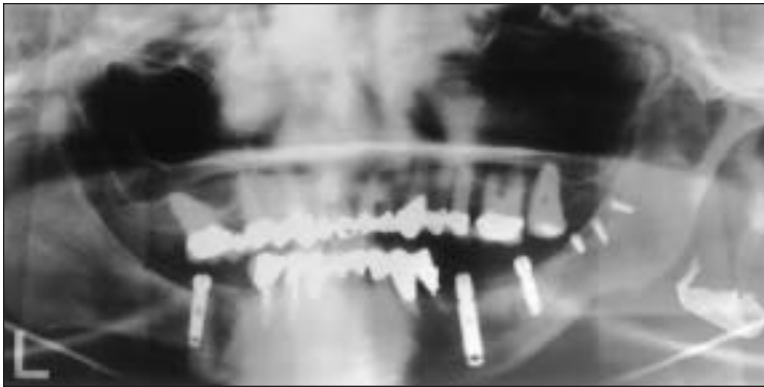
Panoramic radiograph taken approximately 9 months after placement, at the time the patient was referred for restoration of the 3 remaining implants.
